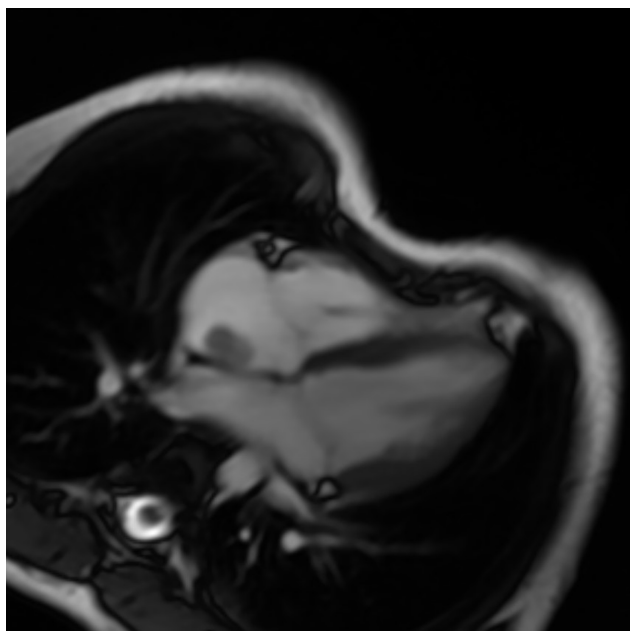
Cardiac MRI showed a 16 × 11 mm pedunculated mobile mass attached to the right side of the atrial septum.
